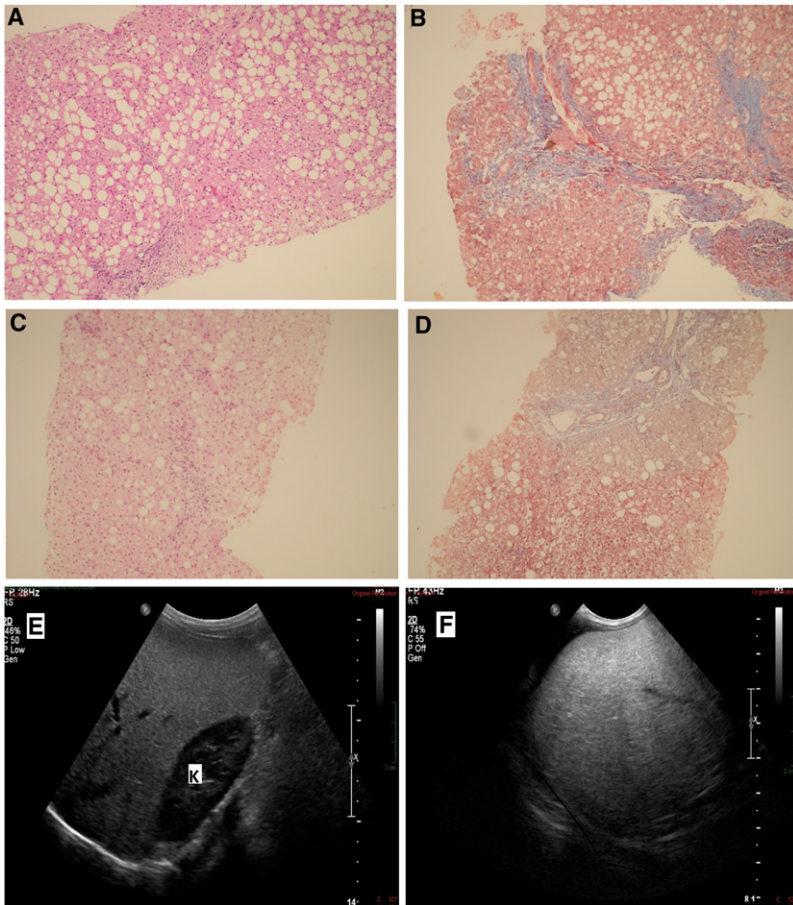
Liver Biopsies and Ultrasound
